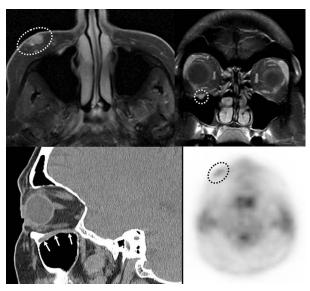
Top: Magnetic resonance images, T1 weighted after contrast with fat saturation demonstrating a soft tissue mass in the right cheek (dotted line, left) and an enlarged infraorbital nerve (dotted line, right). Bottom left: Parasagittal CT image showing an enlarged infraorbital nerve within its canal (arrows). Bottom right: Axial positron emission tomography image with an increased standard uptake value (2.75) in the right cheek (dotted line).
